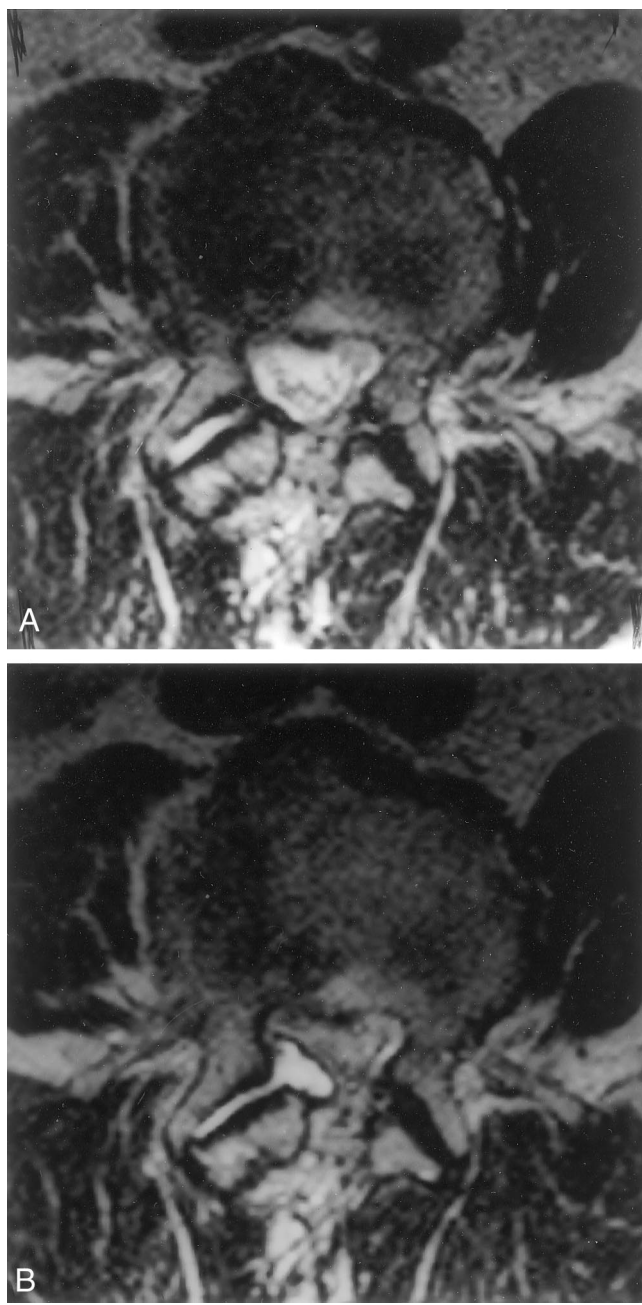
Patient MR 37. Magnetic resonance images (MRI) of L3–L4 in a 77-year-old man who underwent surgery for a spinal stenosis at L3–L5 with decompression 4 years before the current examination. He was pain free for 2 years, but since then has experienced an intractable L4 rhizopathy in his right leg. Results from MRI examination during PRP (A) were normal, whereas examination during ACE (B) showed a large synovial cyst protruding from the right L3–L4 facet joint and affecting the L4 nerve root.
